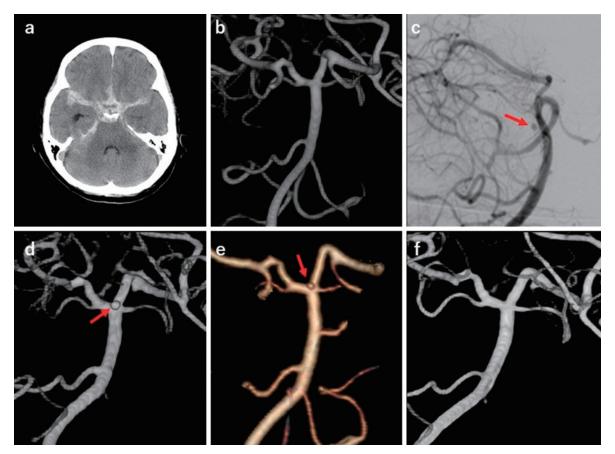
Initial computed tomography image showing diffuse subarachnoid hemorrhage in the bilateral Sylvian fissure and basal cistern (a). On admission, three-dimensional rotation angiography (3D-RA) of the right vertebral artery revealed no vascular anomalies (b). Right vertebral angiography (c) and 3D-RA (d) on Day 22 revealed a microaneurysmal change (arrow) of approximately 2 mm in the dorsal basilar artery. Computed tomography angiography on Day 35 detected a microaneurysmal change (arrow) (e). However, 3D-RA on Day 73 revealed complete disappearance of the lesion (f).
